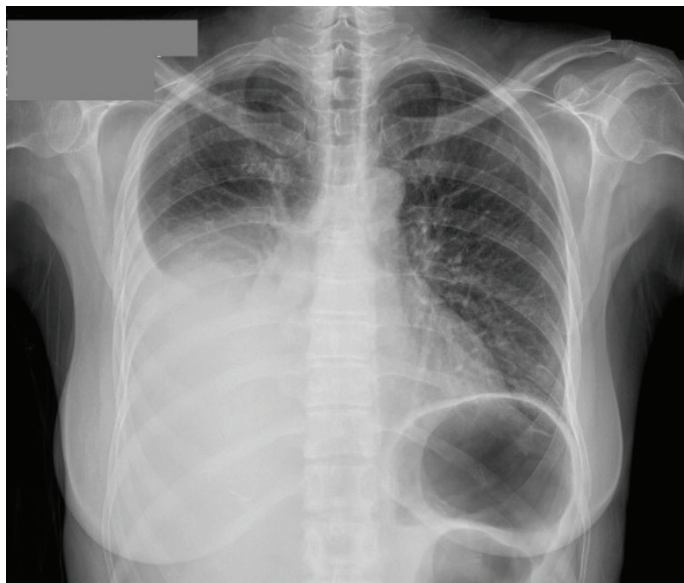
The posterior-anterior chest radiograph showed consolidation and pleural effusion in the middle and lower zones of the right lung.
